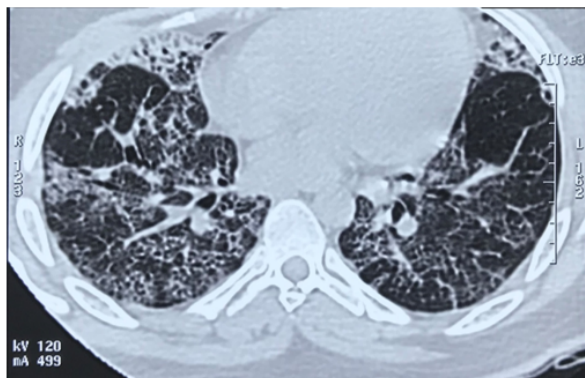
Axial view of the patient's high-resolution computed tomography scan of the lungs revealed COVID-19 reporting and data system grade 5
